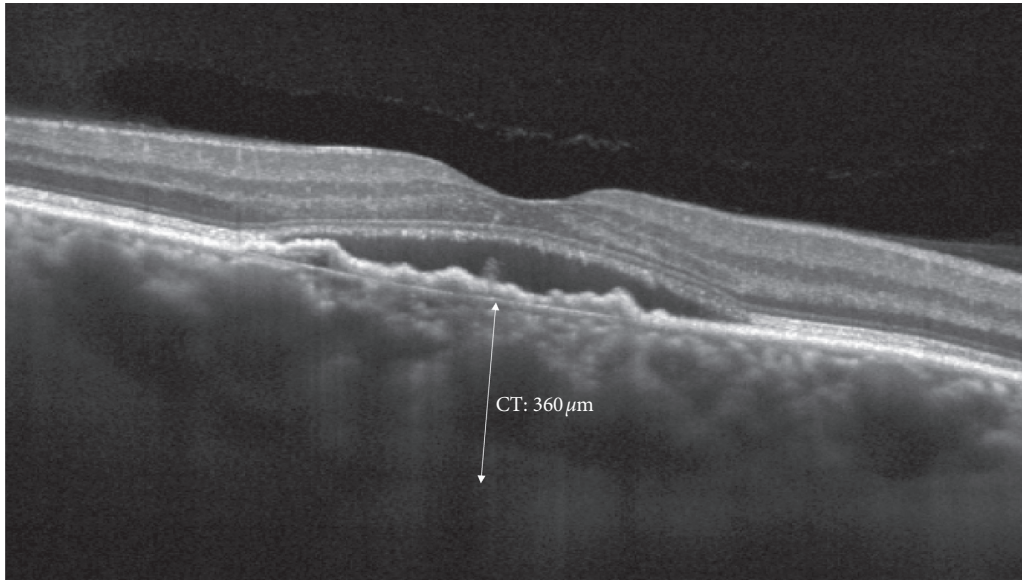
Structural biomarker: manual caliper to measure choroidal thickness (CT).
